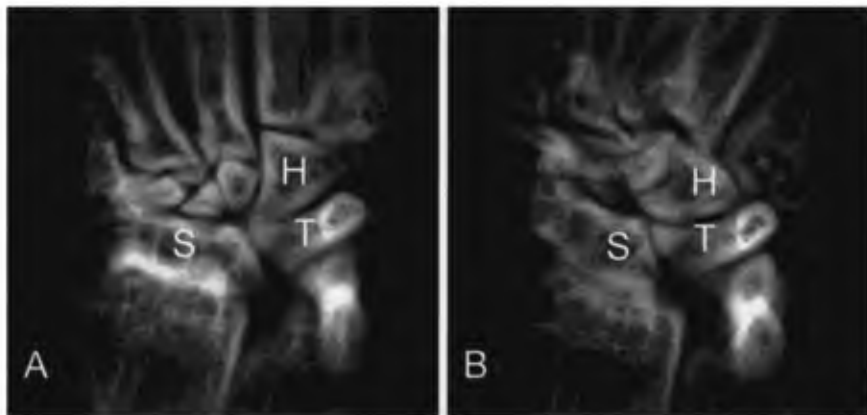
X-ray images of wrist of *Sciurus carolinensis*, showing extent of radial (A) and ulnar (B) deviation permitted.
